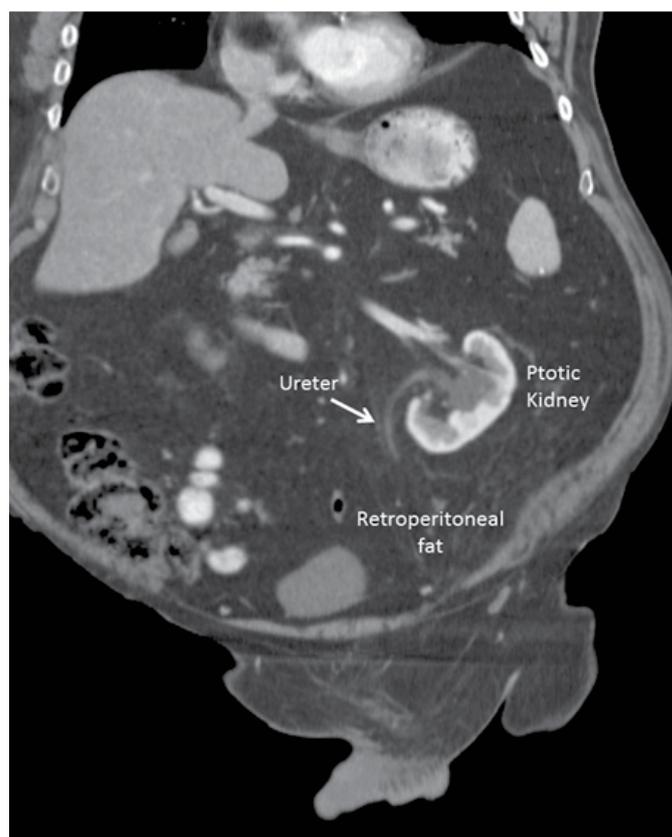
Coronal section of computed tomogram with contrast showing ptotic left kidney and large amount of retroperitoneal fat extending into inguinal canal.
